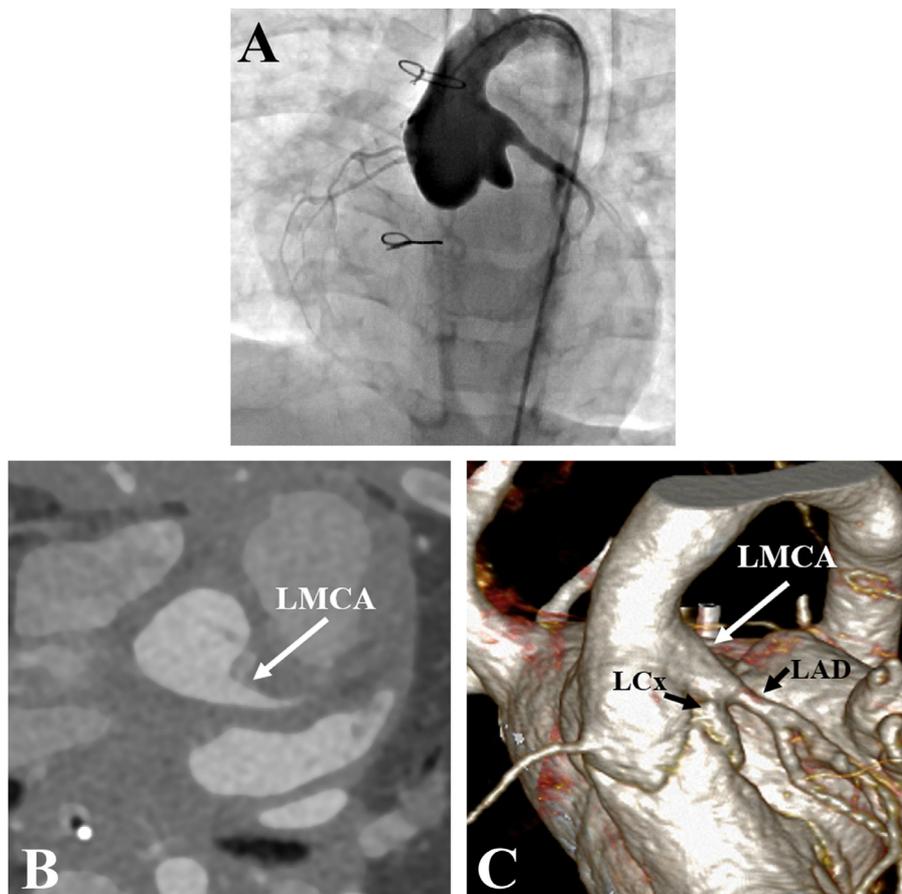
(A) Postoperative aortic root angiogram and (B, C) computed tomography angiography demonstrating successful repair of the obstructive aorta and coronary artery lesions.
